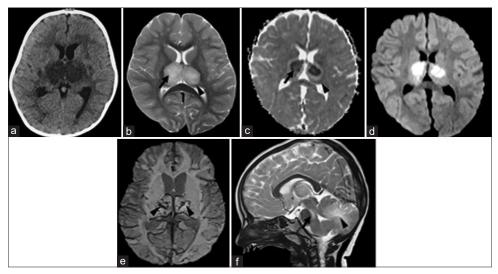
Acute Necrotizing Encephalopathy of childhood (ANEC): (a) Non-contrast CT showing bilaterally symmetrical thalamic hypodensity; (b) Bilateral symmetrical thalamic involvement with edema, T2 hyperintensity (arrowhead), central heterogeneous areas (arrow); (c) Central heterogeneous areas show cytotoxic edema with diffusion restriction and surrounding area of facilitated diffusion on ADC images, note the innermost area with hyperintensity consistent with necrosis giving classical Target-like appearance of thalamus; (d) DWI sequences with central areas of diffusion restriction; (e) foci of haemorrhage on SWI images (arrowheads); (f) Sagittal T2 images shows hyper-intensity in dorsal pons & cerebellar white matter
